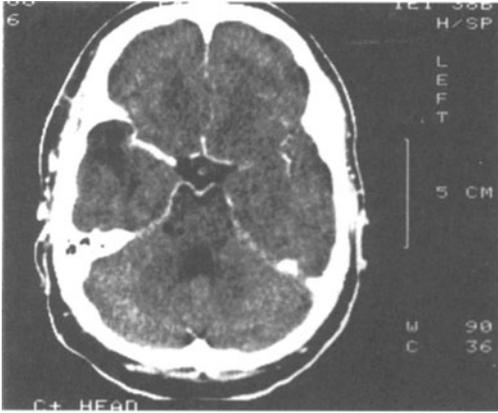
Complex and simple partial seizures: cystic-mixed glial tumor and cortical dysplasia right temporal lobe. Case 22-2. CT scan demonstrated an area of atrophy or cyst right anterior temporal lobe with possible minimum enhancement at the border. This 17-year-old right-handed male, at age 4 years began to have "staring spells and bizarre behavior" with some preceded by the "sound a musical rhythm". An EEG spike discharge was present in the right anterior-middle temporal area. (Refer to text).
